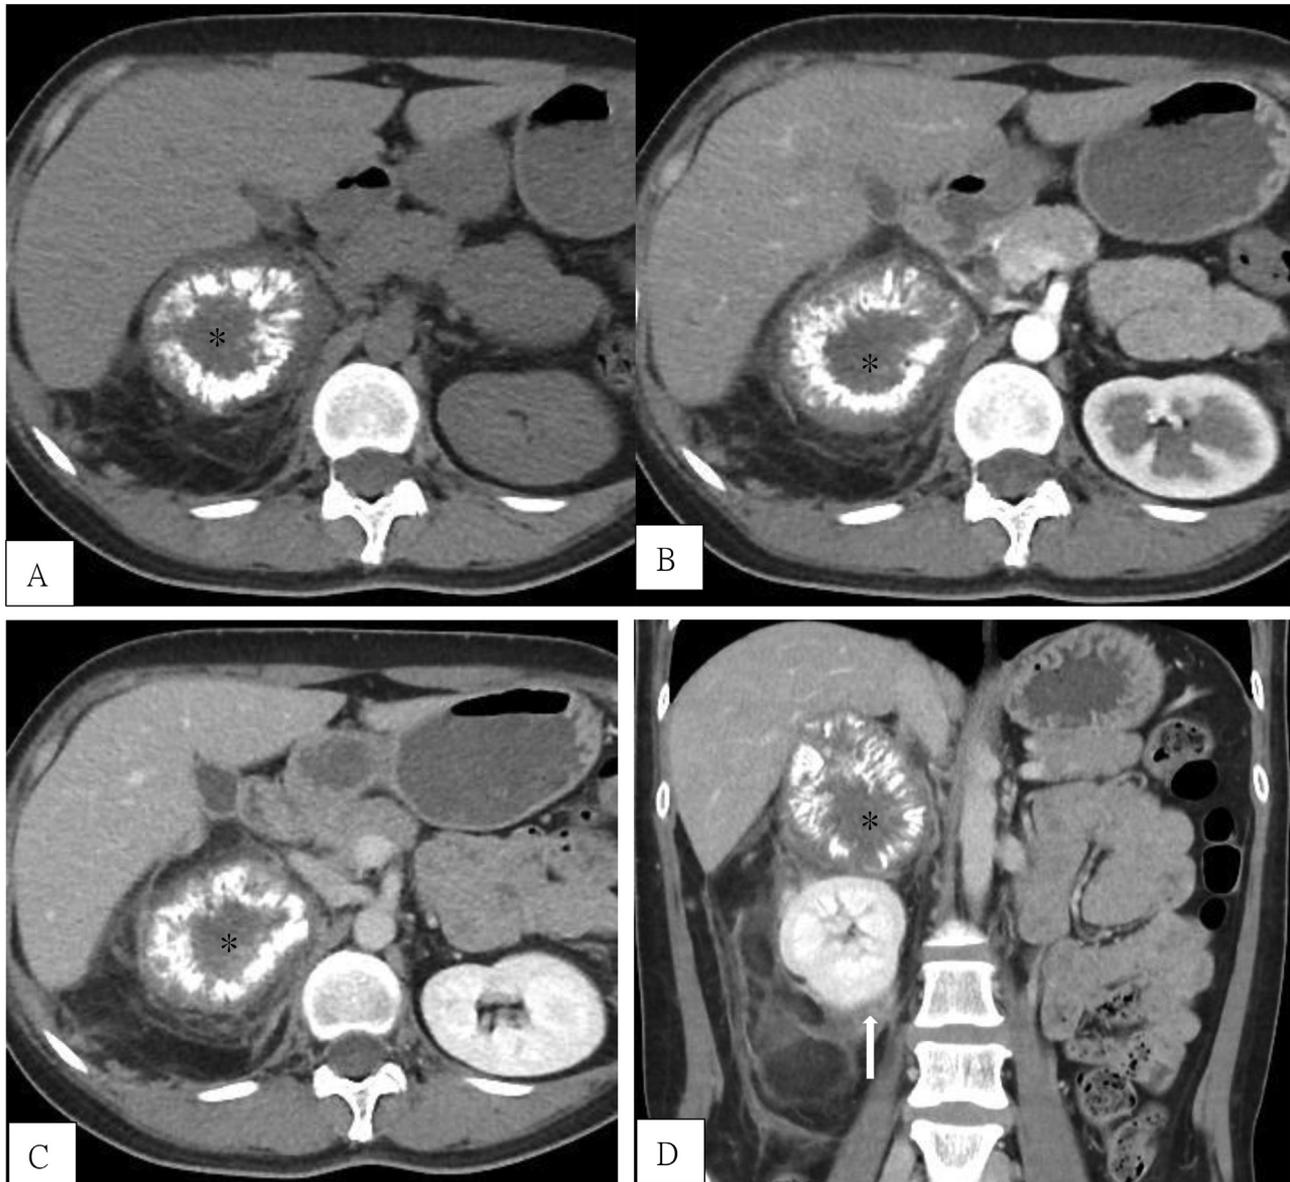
Dynamic abdominal CT, axial scan of noncontrast phase (A), axial scan of corticomedullary phase (B), axial scan of nephrographic phase (C) and coronal reconstruction images of nephrographic phase (D), demonstrate a right suprarenal solid mass with internal numerous curvilinear radiated calcifications (asterisks in A–D) in a sunburst pattern. Soft-tissue content was found inside the fatty component (arrow in D).
